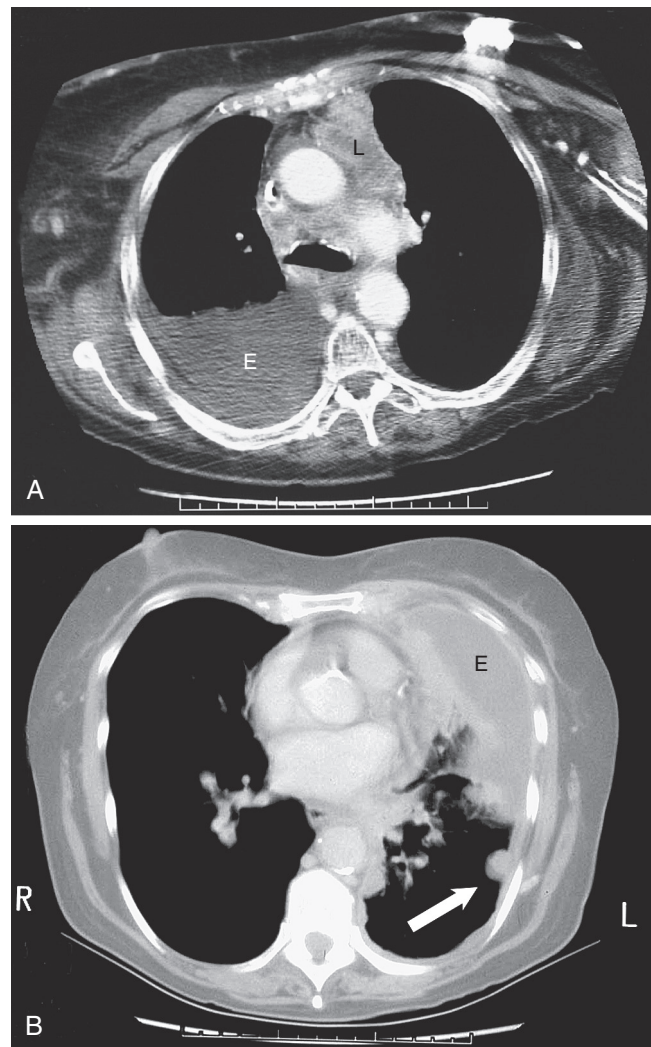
■ A, CT images of a malignant pleural effusion. B, Chest CT from a patient with breast carcinoma, with recurrent basilar left pleural effusion after partially successful chemical sclerosis. The image shows partial pleurodesis, pleural thickening, and a pleural nodule (arrow) at the level of the mid thorax. E, Effusion; L, prevascular lymphadenopathy.
